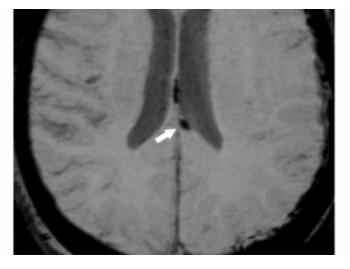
Shear injury is visible in the subcortical white matter of the left frontal lobe in this patient as hyperintense on T1 due to hemorrhage (top row left). The same area is bright on FLAIR due to edema (top row right) and bright on DWI due to cytotoxic edema (middle row left). The SWI (bottom row) also shows low signal blood products in this area. Similar findings in the splenium of the corpus callosum (middle row right, bottom row) and posterior septum pellucidum (bottom row) indicate a grade 2 shear injury and portend a poorer prognosis than if the involvement were only at the gray-white junction. A subacute left subdural hematoma is also visible on each sequence, but most clearly visible as hyperintense on T1 (top row left).
